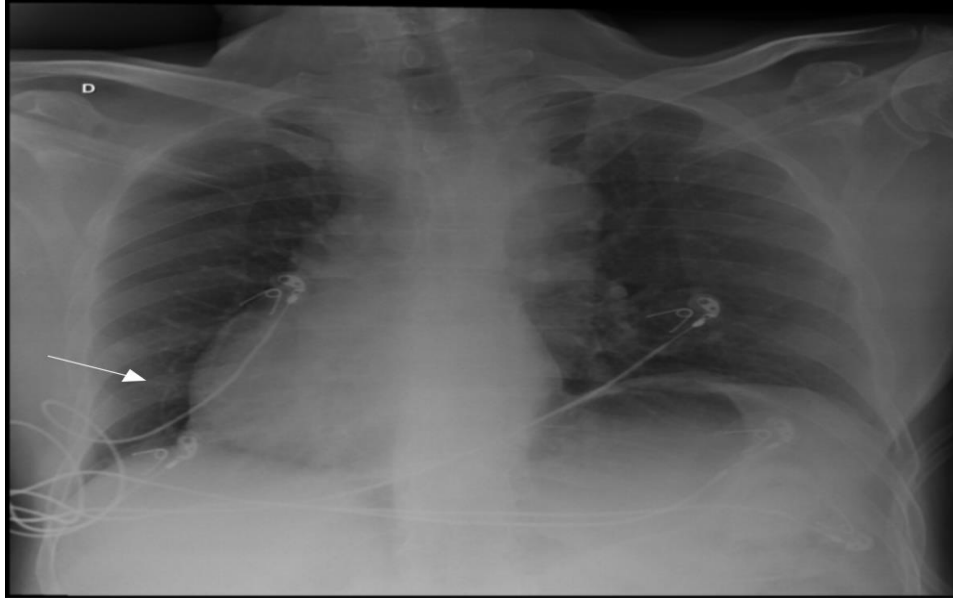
A chest radiography shows apex turned to the right.
